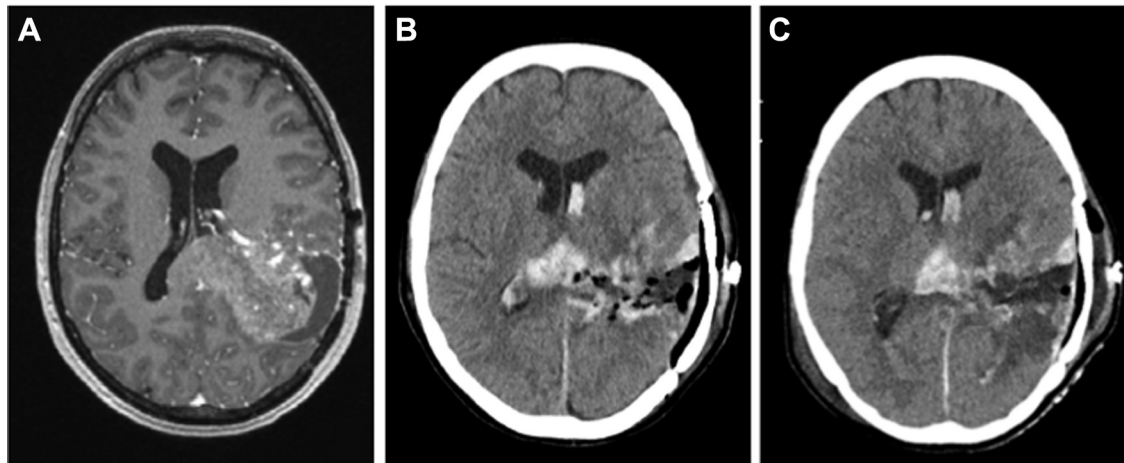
Imaging data. (A) Preoperative magnetic resonance imaging. (B) Postoperative computed tomogram (CT) after surgery. (C) CT Postoperative day 4.
